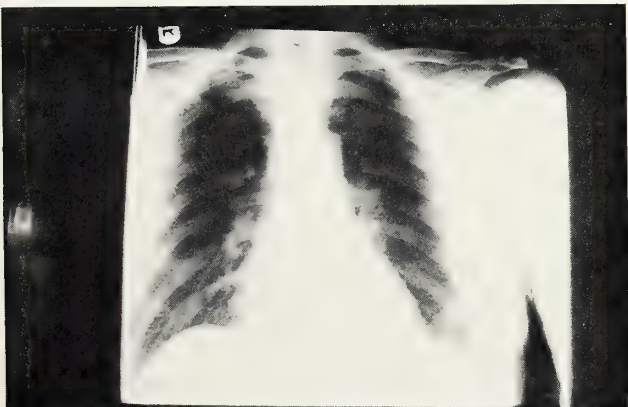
Chest x-ray (first admission) eight weeks before death.
